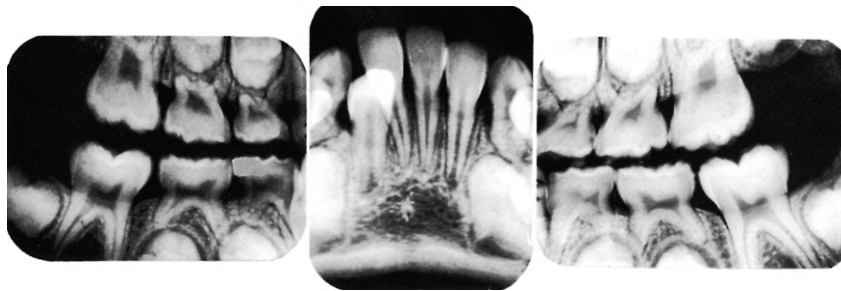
Shown in this radiograph are 6-year molars in position, roots of primary teeth being resorbed, and formation of succedaneous teeth.
